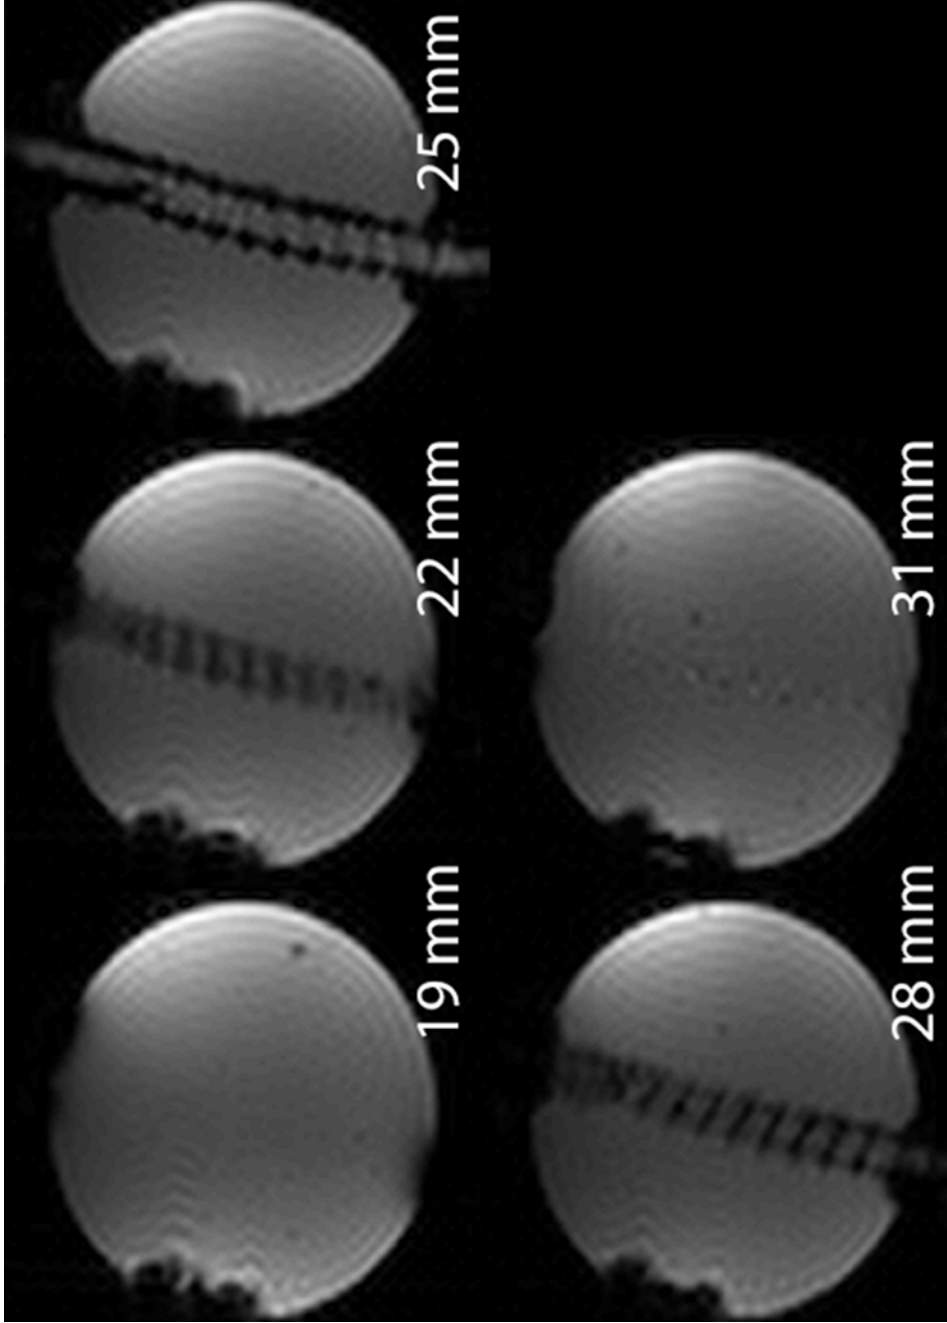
MRI images of graft model at temperature planes. Distances are measured from the face of the graft model nearest the transducer. Images are perpendicular to the direction of ultrasound propagation.
